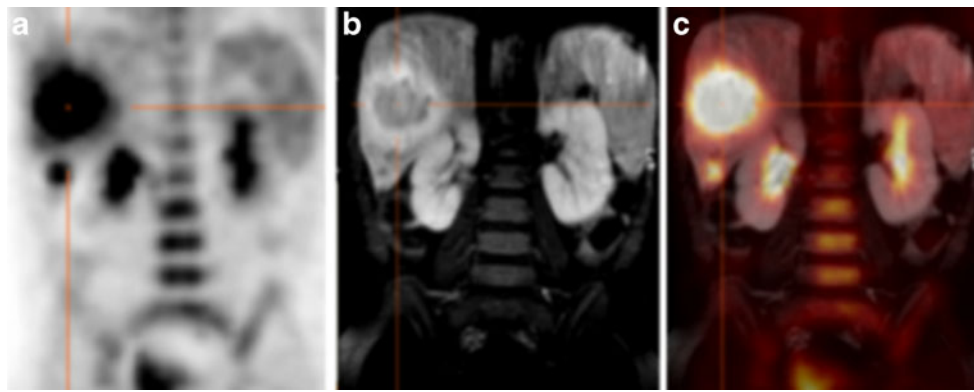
A 4-year-old-boy with abdominal pain—false-positive on ^{18}F -FDG PET/MRI. During primary diagnosis, ^{18}F -FDG PET (a) shows increased uptake in two intrahepatic lesions. MRI (b fat-suppressed T1-weighted sequence after contrast application) and registered images (c)
